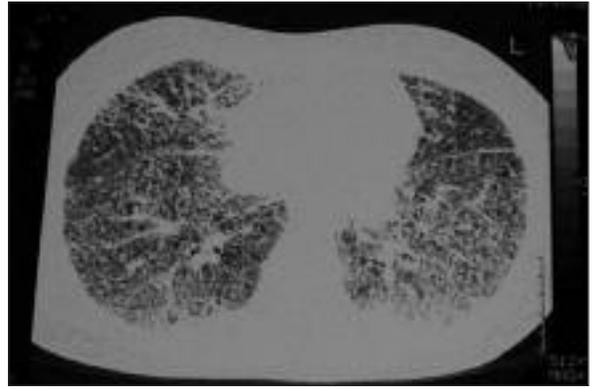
High resolution computed thoracic (HRCT) scan: subpleural interstitial thickening, interlobular septal thickening, and diffuse micronodules in bilateral lower lobes.
